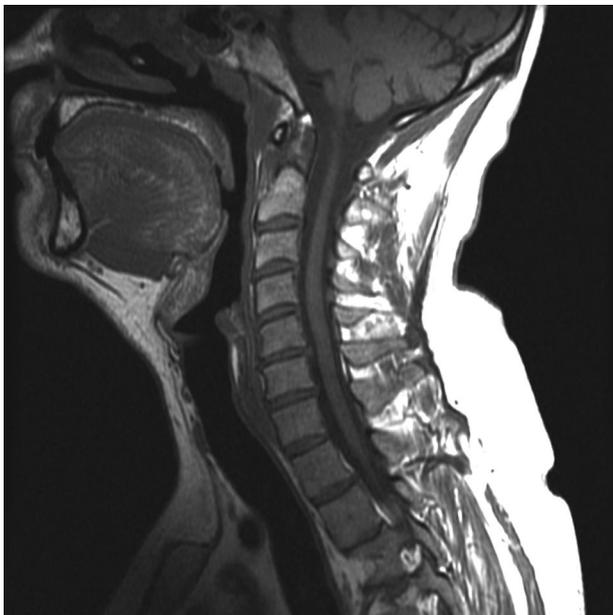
Mid-sagittal T2 magnetic resonance image of 50-year-old male with a body mass index of 24.
